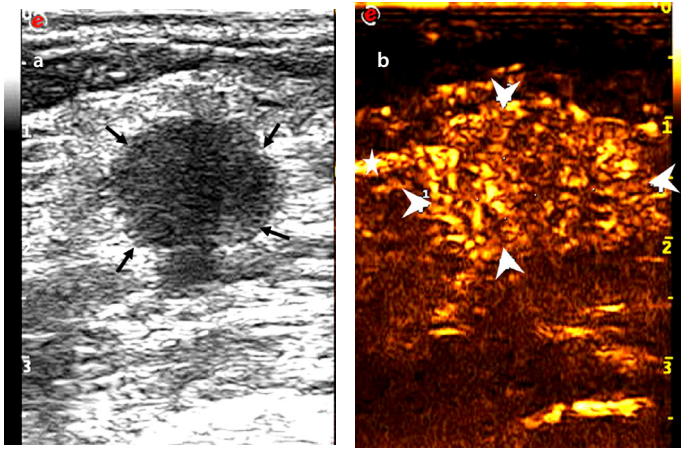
Images of a 53-year-old female diagnosed with invasive ductal carcinoma in the right breast: (a) tumor with a maximum diameter of 1.7 cm showed a circumscribed margin on the conventional ultrasound (thin arrow), and no suspicious axillary lymph node was observed; (b) tumor with an extended range of 2.1 cm showed an unclear boundary (thick arrow) and vessel perforation entering from surrounding tissue into the mass (fine arrow). One-node macrometastasis was found in the final pathological results.
